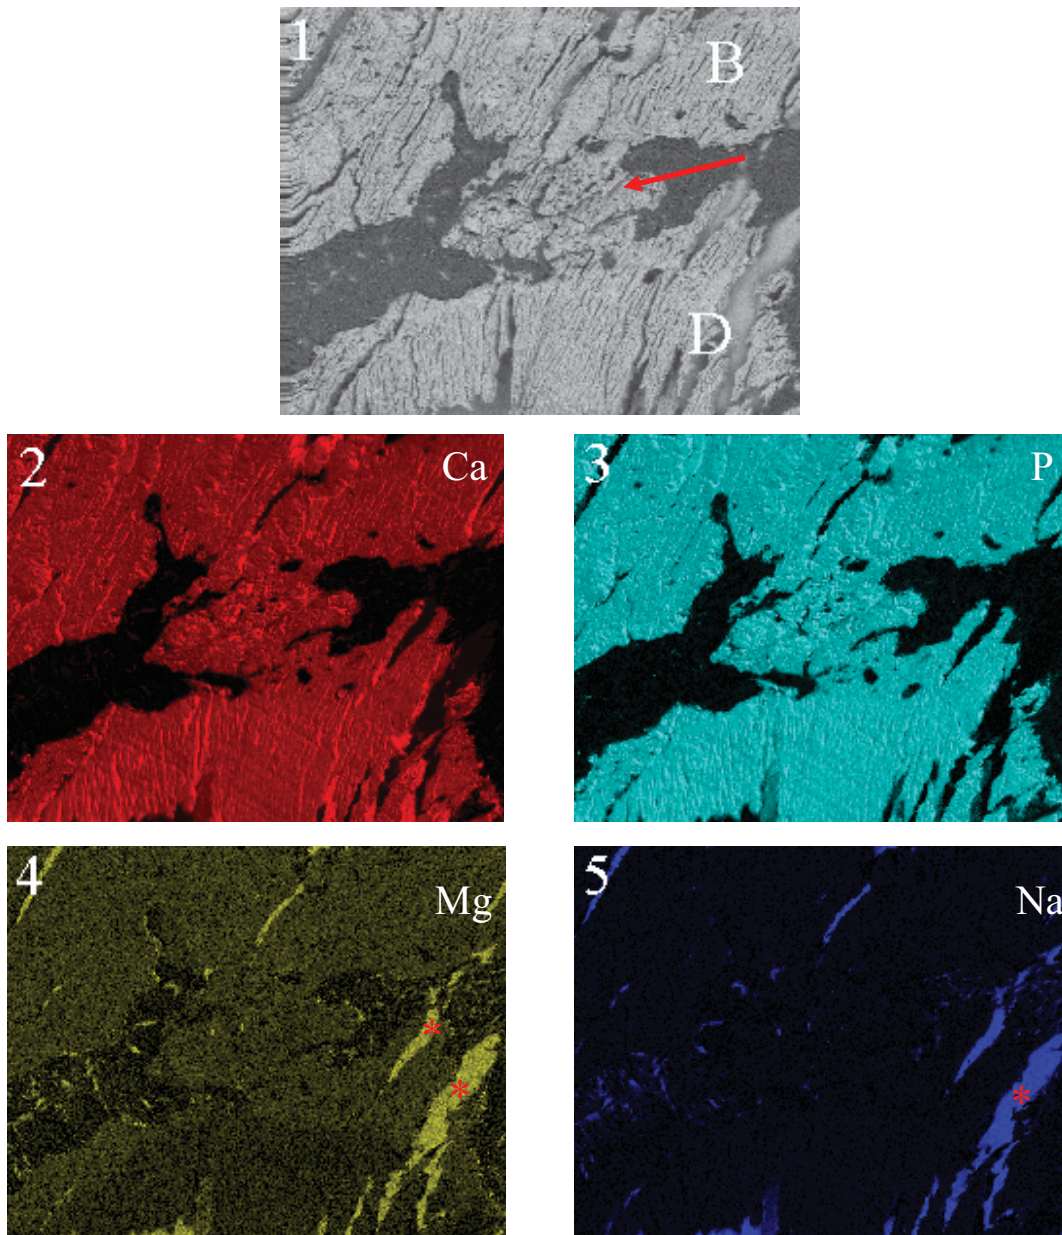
Colour mapping by wt% of Ca, P, Mg and Na. 1. BSE image of ankylotic area (red arrow). B=alveolar bone, D=dentine. 2. Calcium distribution as characterised by red. The more intense the colour, the higher the weight percentage of the element. 3. Phosphorous. 4. Magnesium, 5. Sodium. Asterix (*) indicates tears in the section, exposing the underlying glass slide for x-ray analysis.
